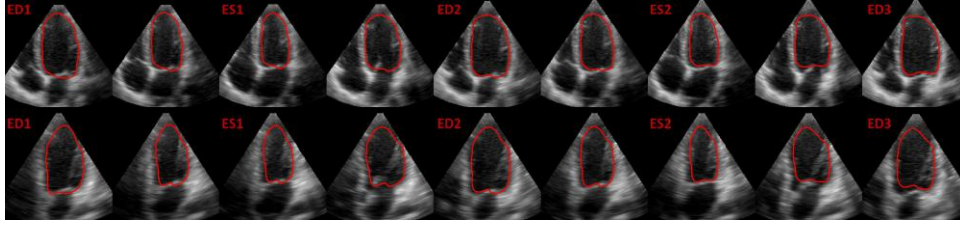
Tracking of the LV in a RT3DE dataset using the proposed hybrid approach (top: apical 4 chambers view, bottom: apical 2 chamber view).
